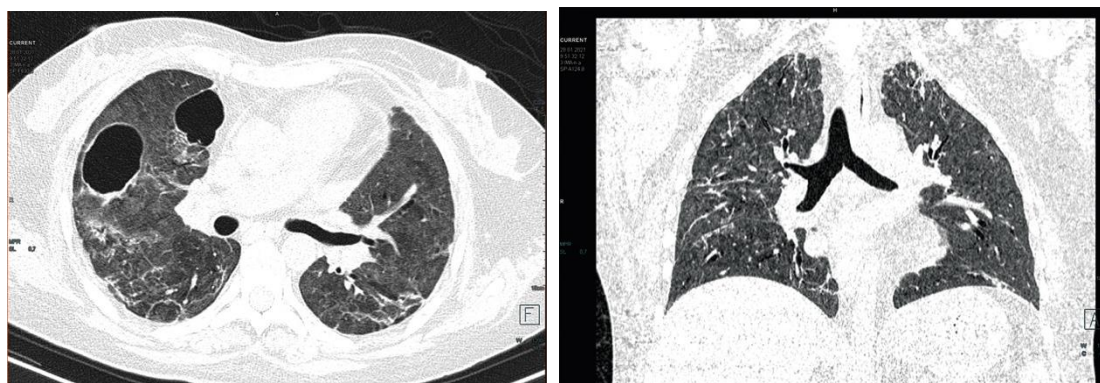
Computed tomography of the chest organs on the 59th day of inpatient treatment
